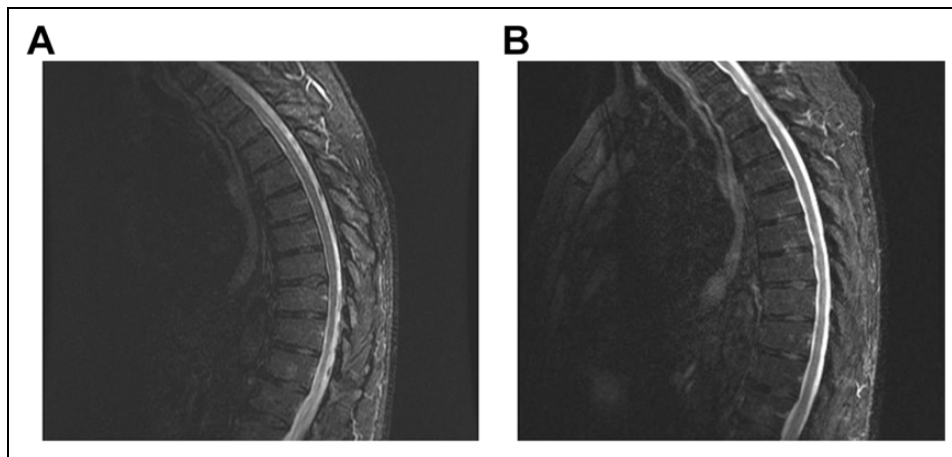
A, 1.5 T magnetic resonance imaging (MRI) thoracic spine short tau inversion recovery (STIR) sequence on admission, (B) 3 T MRI thoracic spine STIR sequence at 3 weeks.
